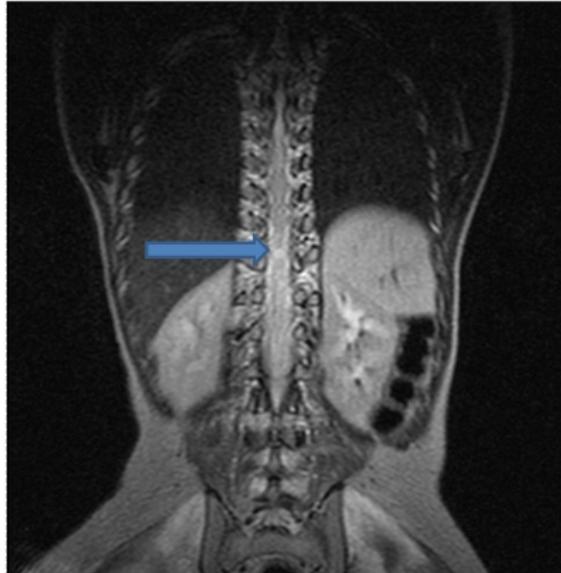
Coronal view of T2 weighted spinal MRI showing area of hyperintensity on thoracic segment of the cord
